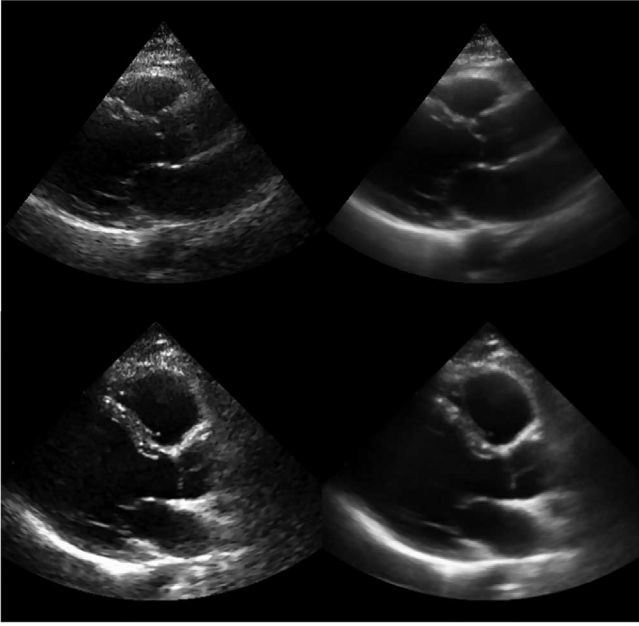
Original (left) and compound (right) parasternal long axis ED frames of average (top) and high (bottom) image quality and diagnostic value. The images are generated using the temporal compounding approach as described in [105] and [112]. Compounding suppresses tissue speckle and chamber noise substantially. Structures such as the IVS, RV, and aortic valve (top) and the RV and aortic valve (bottom) are enhanced without any noticeable blurring across cardiac tissue and cavities. The figure has been reproduced with relevant permission from [112].
